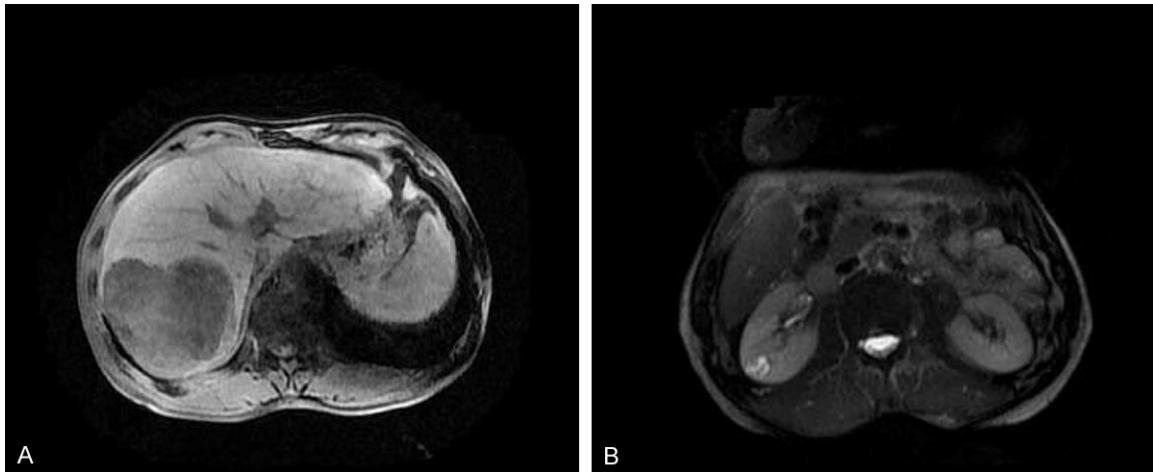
Contrast-enhanced computerized tomography (CT) scanned images of the abdomen at portal venous phase. A. A 9.3 cm × 8.7 cm mass in the hepatic posterior lobe. B. Another 1.6 cm × 1.5 cm mass occupying the lower portion of right kidney without local invasion or lymphnode metastases.
